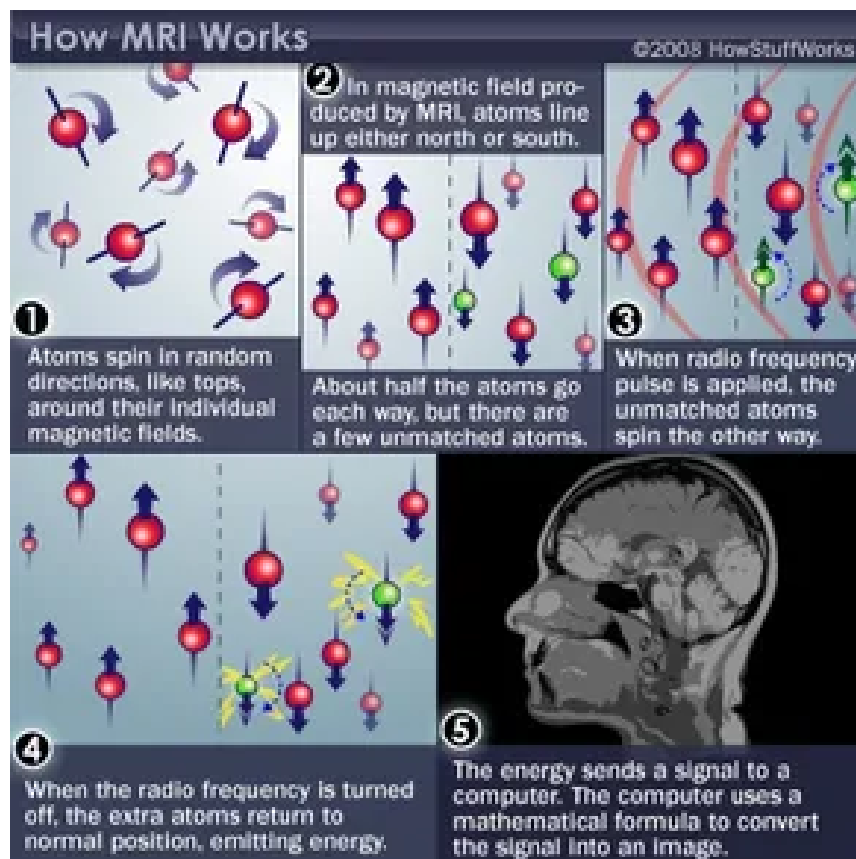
MRI technology works using a magnetic field, radio pulse, and the ability to capture the energy to generate detailed internal images (29).
